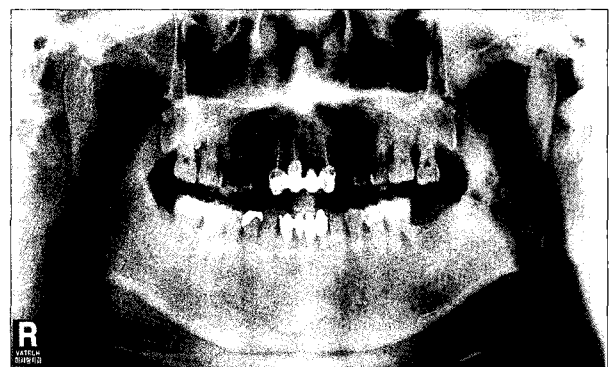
Panoramic radiograph showing no specific pathosis on the lower left molar area.
